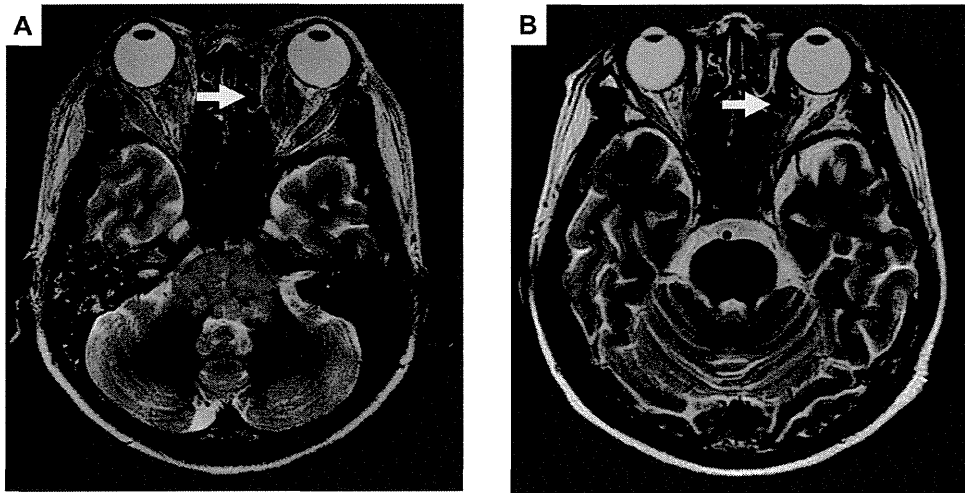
Pre (A) and post (B) treatment brain magnetic resonance imaging of metastases of right extraocular muscles showing a partial response (arrows).
